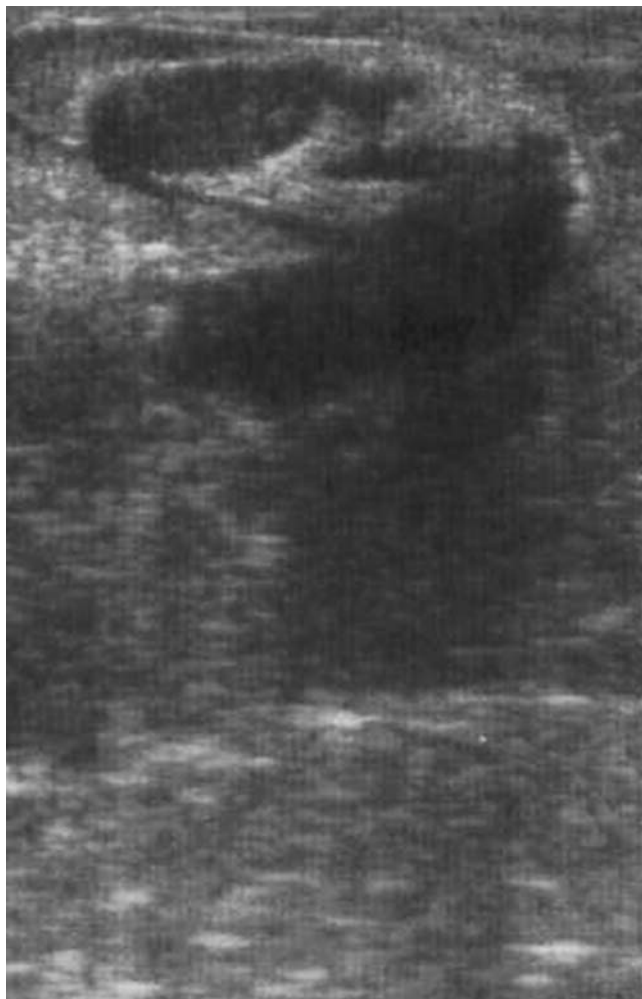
Ultrasound image of subcutaneous abscess showing irregular hypoechoic oval collection in subcutaneous tissue.
